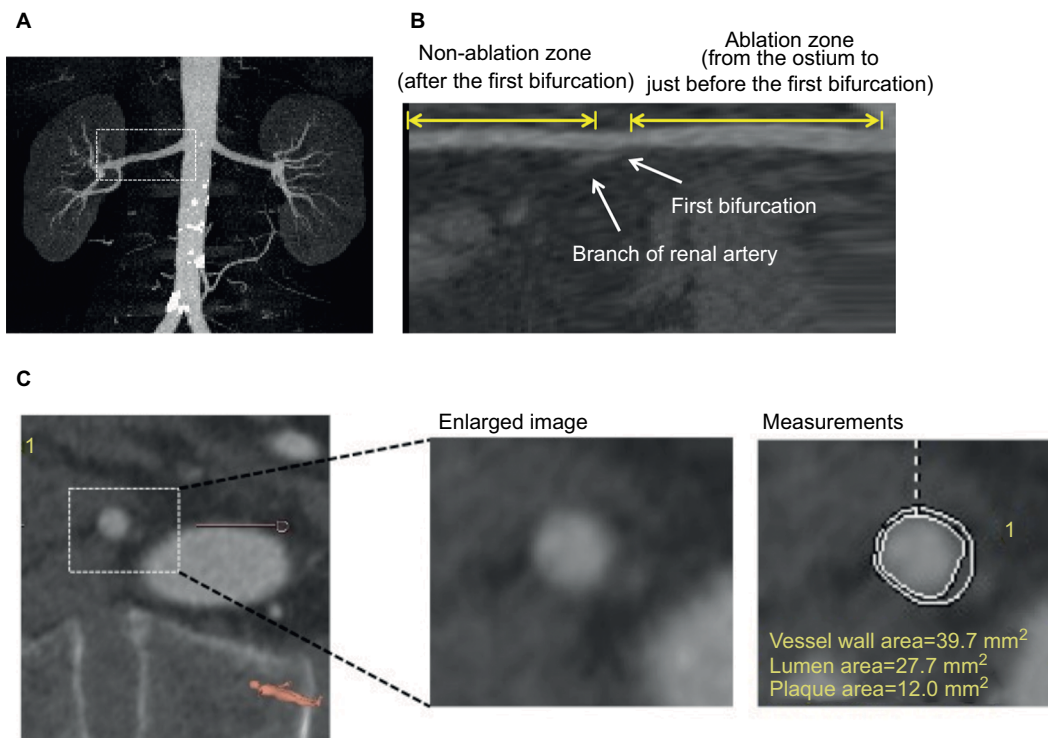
Volumetric CT analysis of vessel wall in renal arteries.
